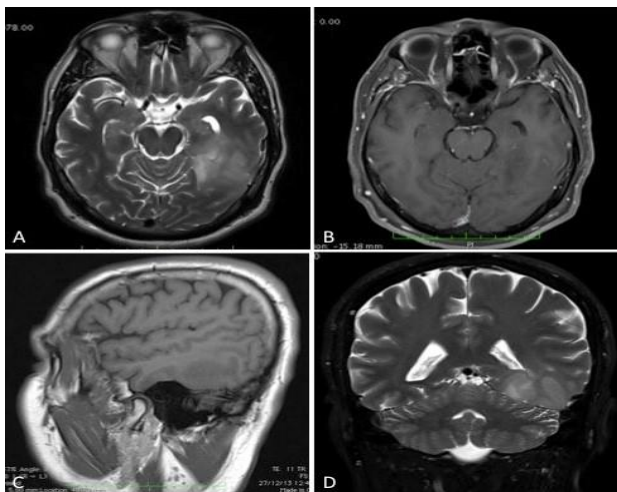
Patient's initial MRI showing heterogenic and infiltrative tumour on axial, sagittal and coronal T2 scans.
